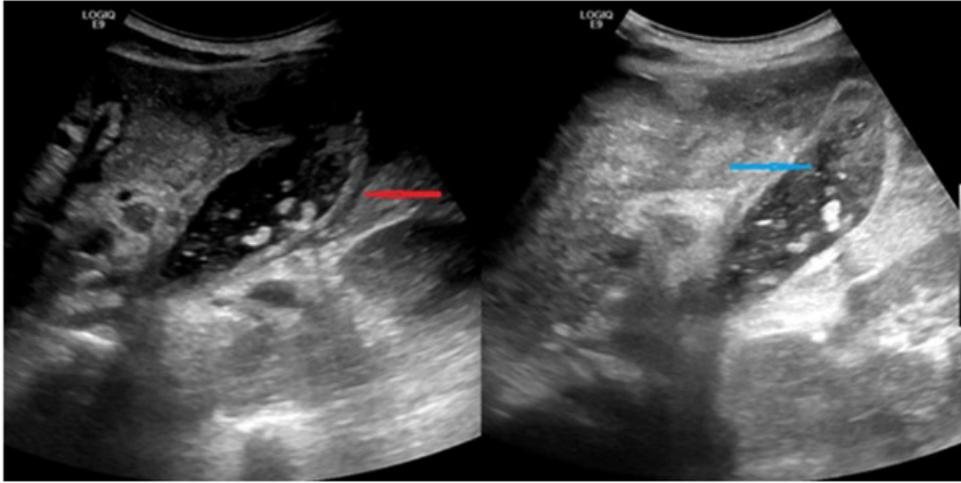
ultrasound imaging showing thickening of the gallbladder wall (red arrow) with a heterogeneous content (blue arrow).
